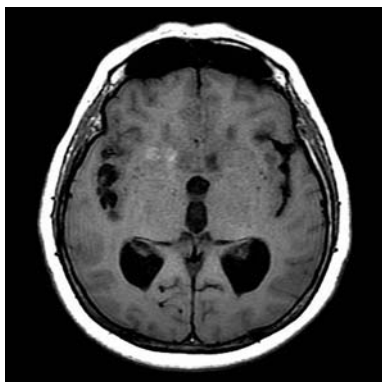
T1-weighted image showing hypointense lesions suggestive of cystic lesions.
